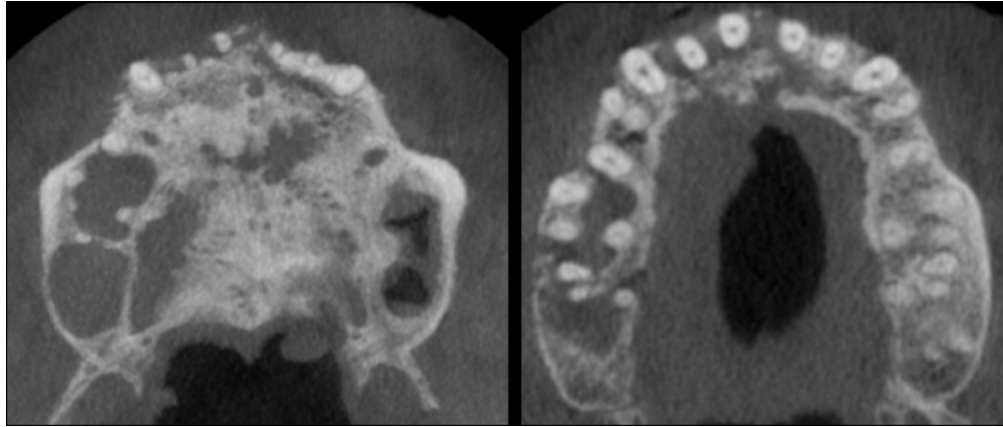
Shows an axial section of CBCT which depicts the loss of buccal cortical plate along with osteopenia in the region of 15, 16, 17.
